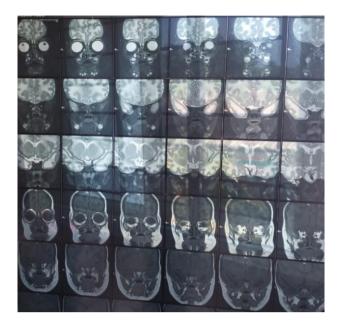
MRI suggesting craniosynostosis (trigonocephaly) due to early fusion of the metopic suture
